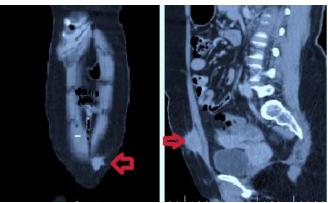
CT scan axial, coronal and sagittal section demonstrates abdominal wall endometrioma with streakiness in surrounding tissue with normal both ovaries (small arrows).
